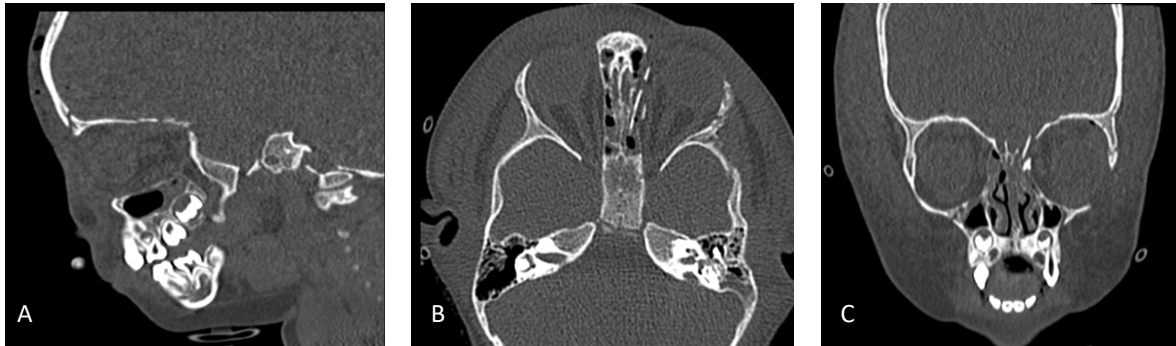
Postoperative CT scans showing sagittal (A), axial (B), and coronal (C) views, respectively
